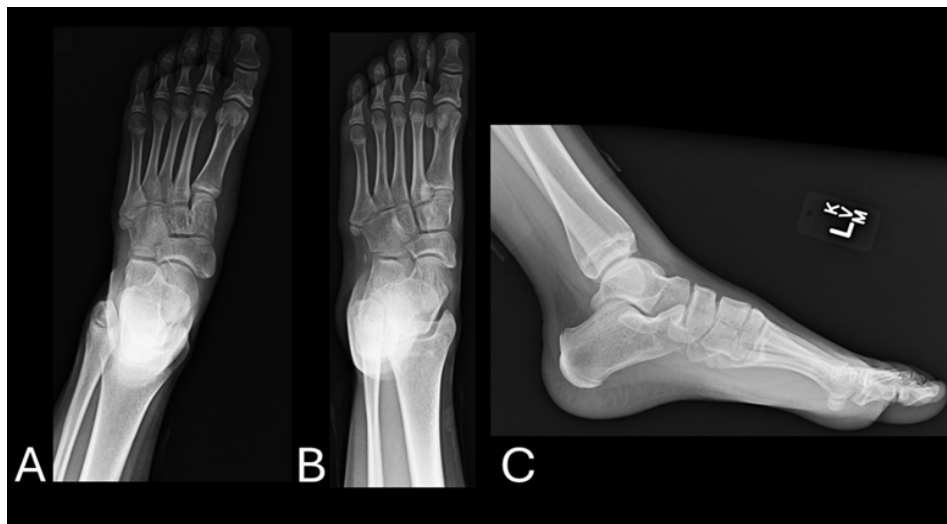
(a, b, c) initial anteroposterior, oblique, and lateral radiographs of the left foot showing an abnormality at the base of the fifth metatarsal.
